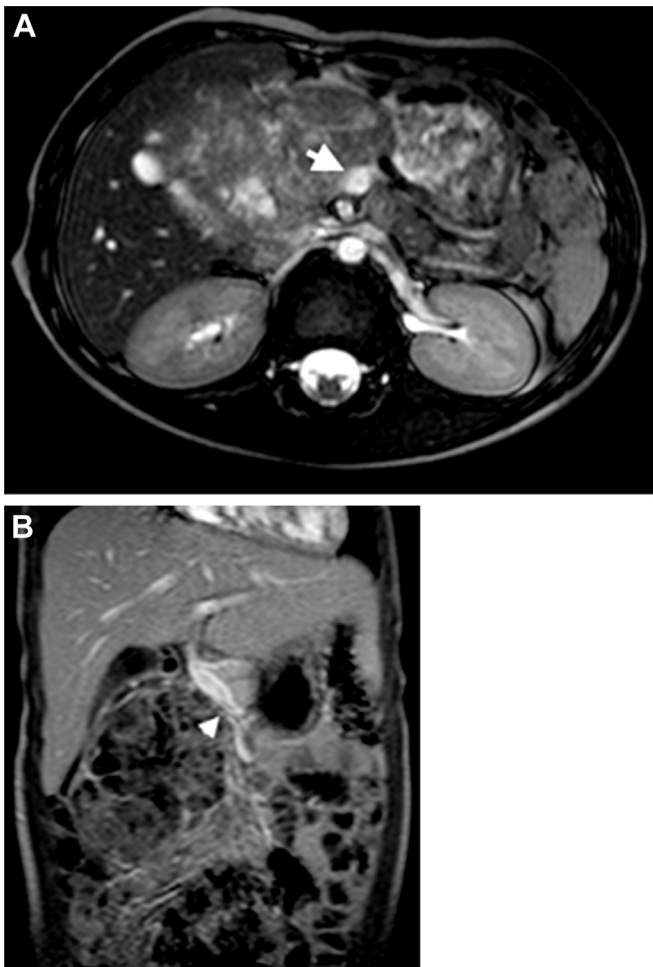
(A) Case 1: Preoperative magnetic resonance imaging (MRI) showing tumor in the head of the pancreas encasing the superior mesenteric vein (arrow), (A) Axial MRI, (B) Frontal MRI. The tip of the arrow in the figure indicates the head of the pancreas tumor that wraps around the superior mesenteric vein.
